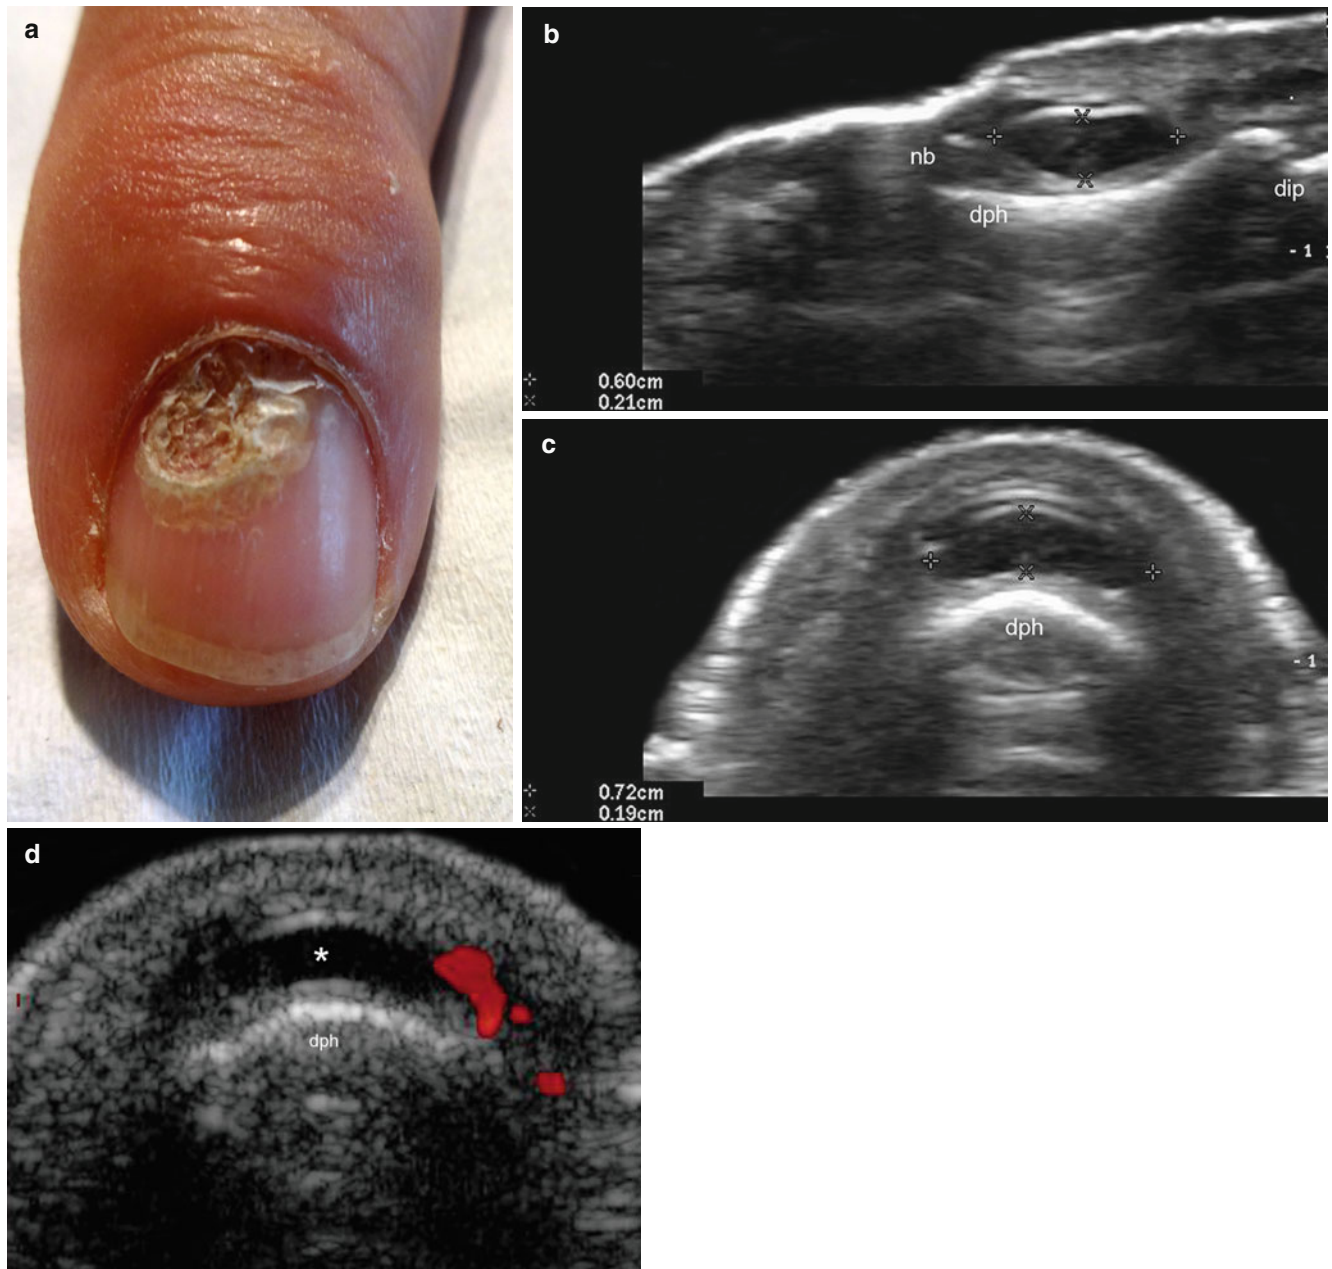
(a–d) Synovial (myxoid) cyst. (a) Clinical image shows deformation and dystrophic changes in the proximal region of the nail plate of the left index finger. (b, c) Grey scale ultrasound images (b) longitudinal view; (c) transverse view) show a 6.0 mm (long) \times 2.1 mm (depth) \times 7.2 mm (transverse) well-defined, oval-shaped anechoic structure in the proximal nail fold that bulges into the nail bed and mildly
